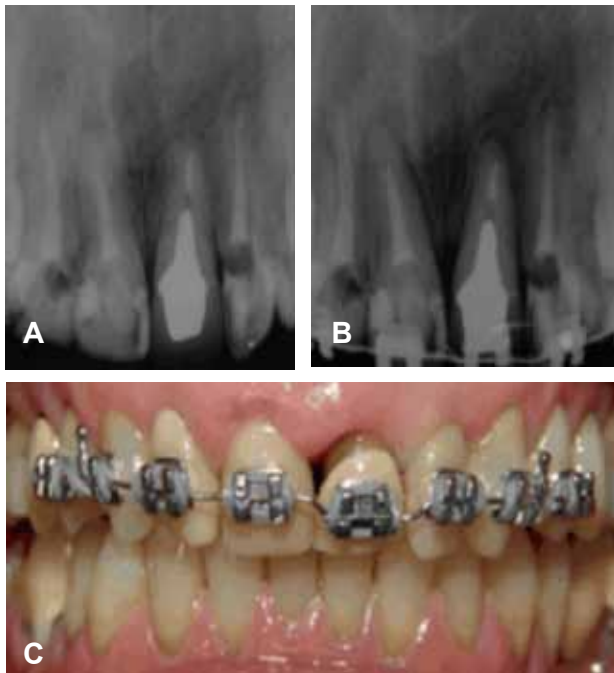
Case 2: A) Initial radiograph. B) Tooth 21 being extruded. C) Tooth 21 extruded.
